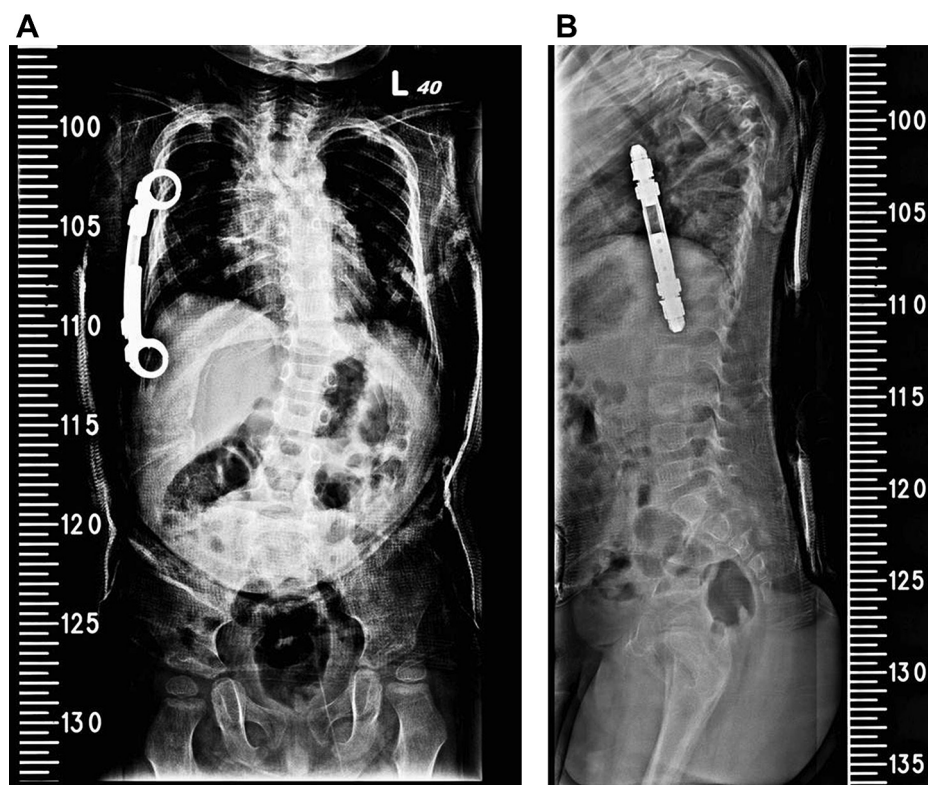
Postoperative radiography of the 2-year-and-10-month-old boy: (A) anterior–posterior view and (B) lateral view.
